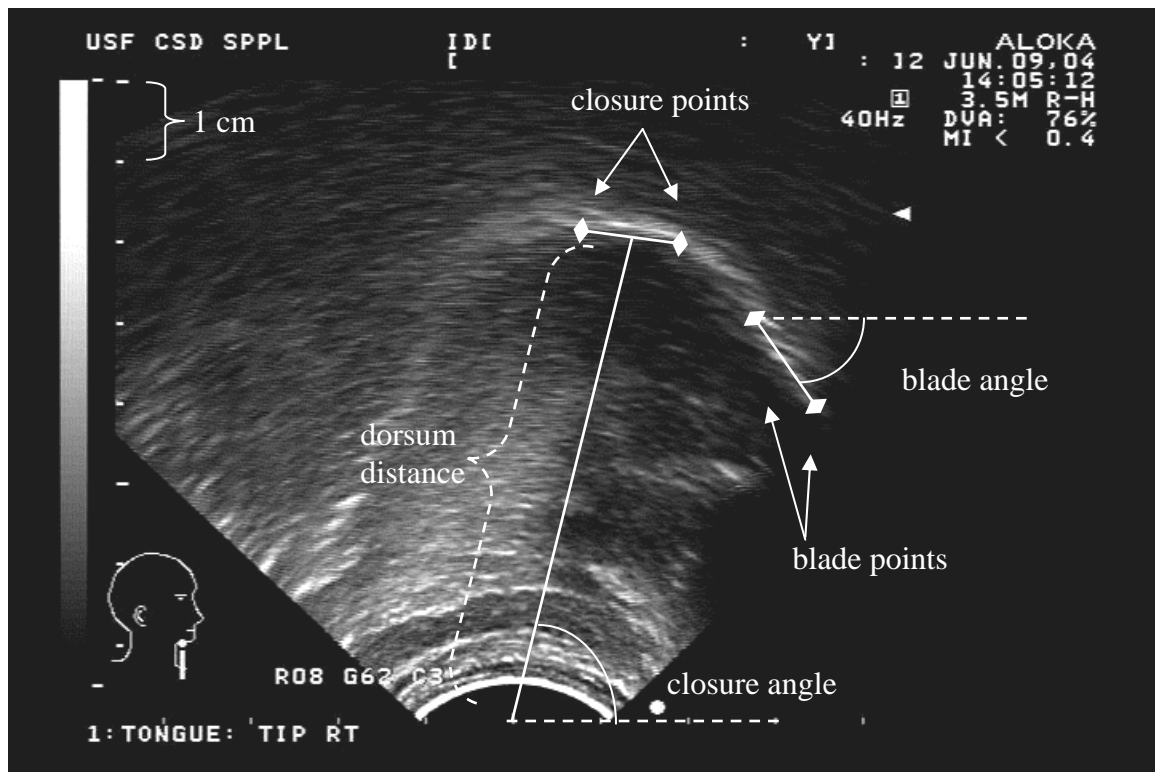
Measurements applied to ultrasound image of the tongue
